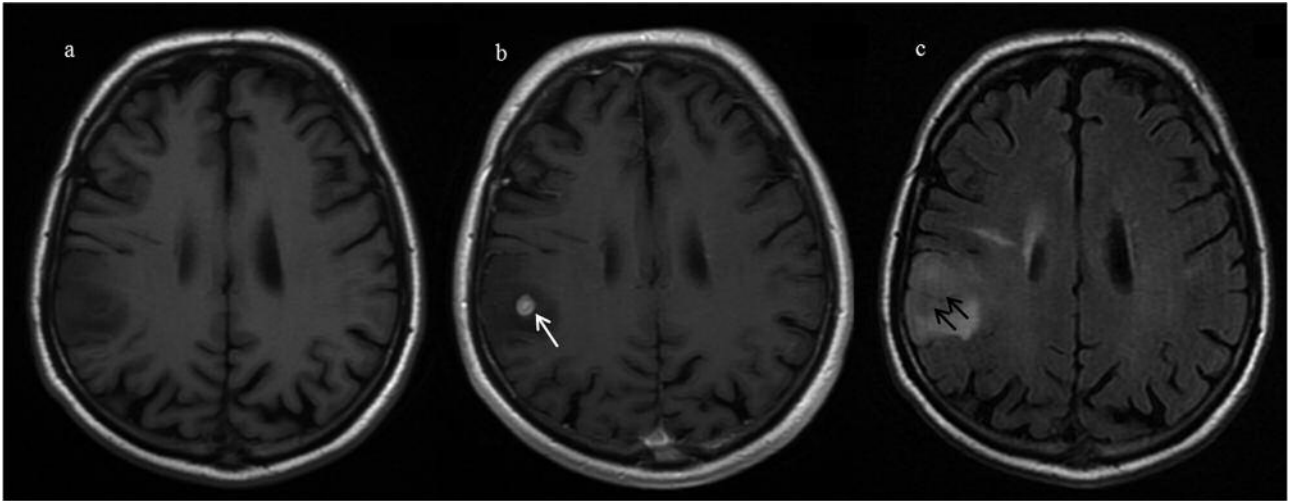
Glioblastoma. Axial FLAIR T1-weighted (a), contrast-enhanced FLAIR T1-weighted (b) and unenhanced FLAIR T2-weighted images. This contrast-enhancing lesion shows a peripheral thin rim of more intense enhancement (white arrow in b), associated with high signal intensity of the adjacent cortex (SAAC) on the unenhanced FLAIR T2-weighted axial image (black arrows in c), i.e. the sign of involvement of the adjacent brain.
